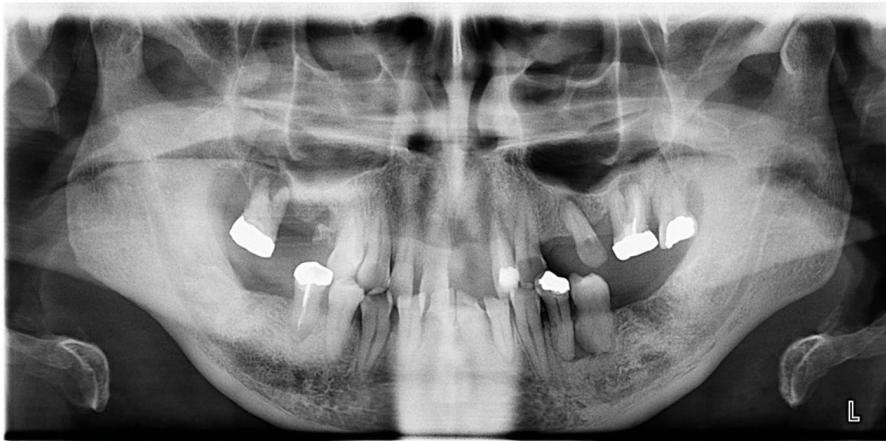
Shows a dental panoramic tomograph of a stage IV lung cancer patient with metastases to the spine, brain and adrenal gland currently under active oncology with monthly pembrolizumab and monthly intravenous bisphosphonates. The radiograph highlights extensive chronic dental disease and a failing dentition though the patient remains asymptomatic. A palliative dentistry approach is adopted to avoid disruption of his oncology regimen
